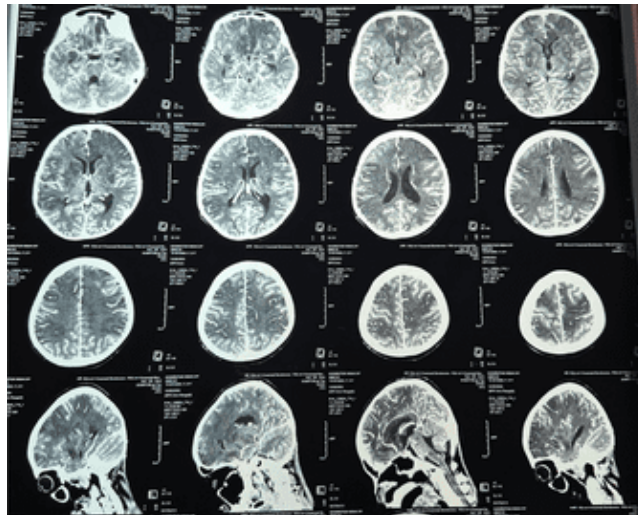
Head CT Scan With Contrast Showed Multiple Infarctions In The Bilateral Frontal, Temporal, and Parietal Lobes and Bilateral Lentiform Nuclei Of The Bilateral Corpus Callosum
